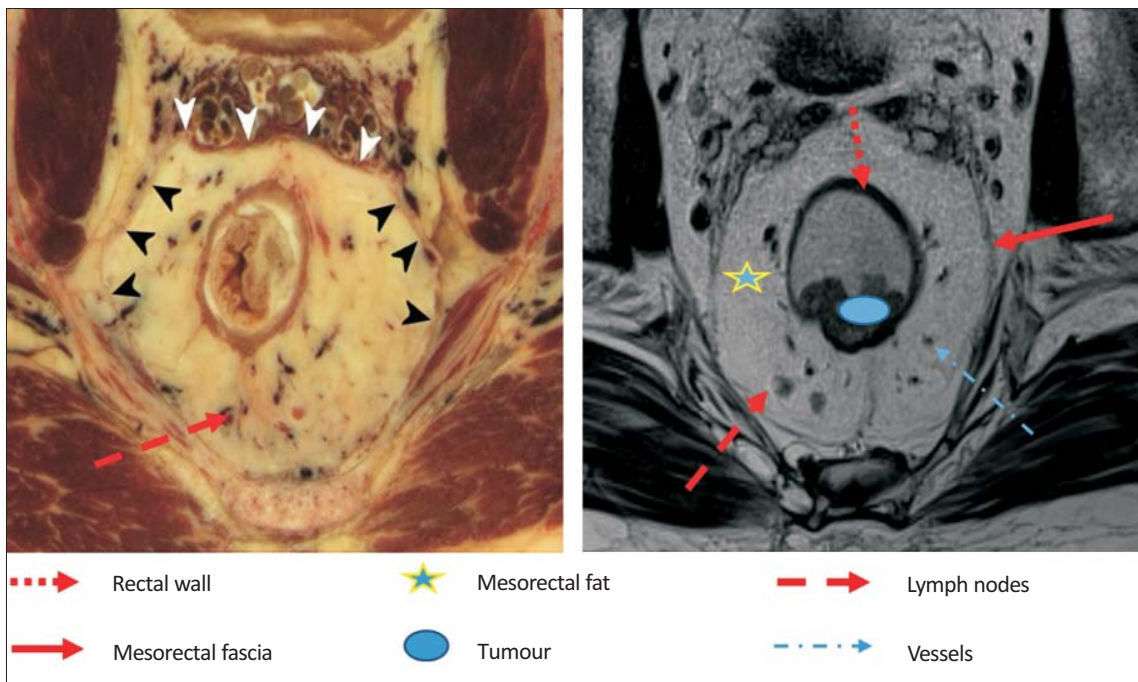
(A) Anatomical preparation. We see the mesorectal fascia as a delicate line (triangles) covering the mesorectal compartment with the rectum, the mesorectal fat, the blood and lymphatic vessels and the lymph nodes. (B) The axial plane T2-weighted FSE image (TSE) corresponding to the anatomical preparation.
